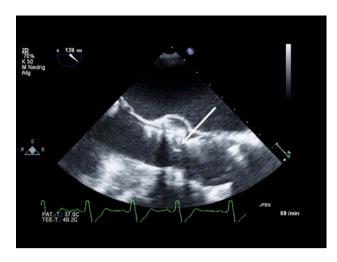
Transoesophageal multiplane echocardiography after TAVI: longitudinal axis with one leaflet with pathologic movements (*white arrow*)
